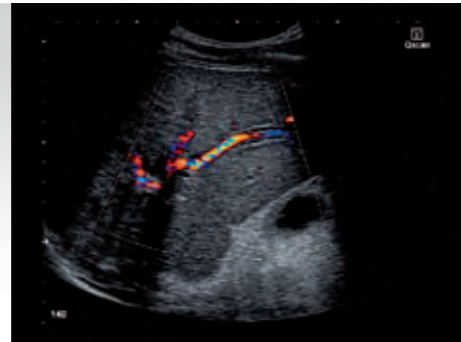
Colour Doppler sensitivity of the Viamo (left) is nearly as good as the Aplio XG (right). There is little artefact and the dilated intrahepatic ducts are clearly visualized.
